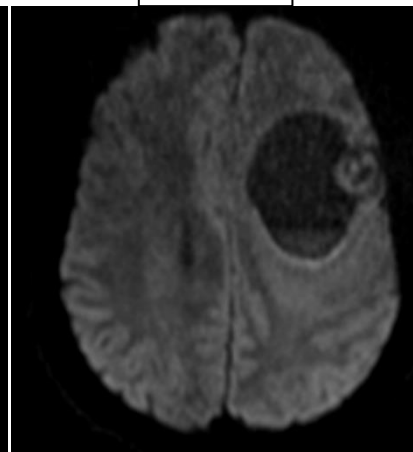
& FIG. 10: ON DWI AND ADC THERE IS NO SIGNIFICANT DIFFUSION RESTRICTION NOTED WITH IN THE LESION.
